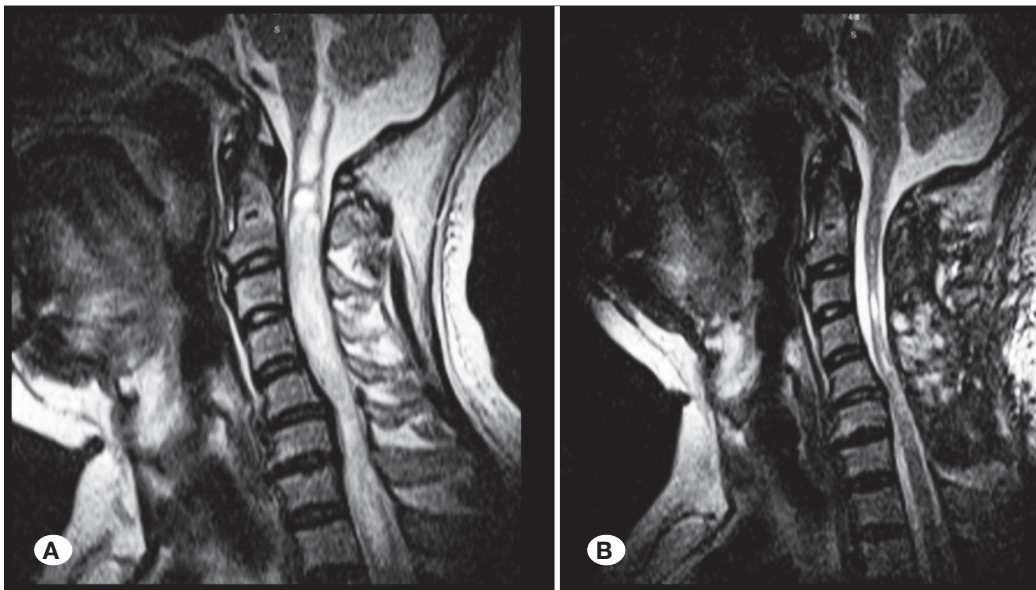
(Patient #19) T2W sagittal MRI scans. Preoperative (A) and postoperative (B).
